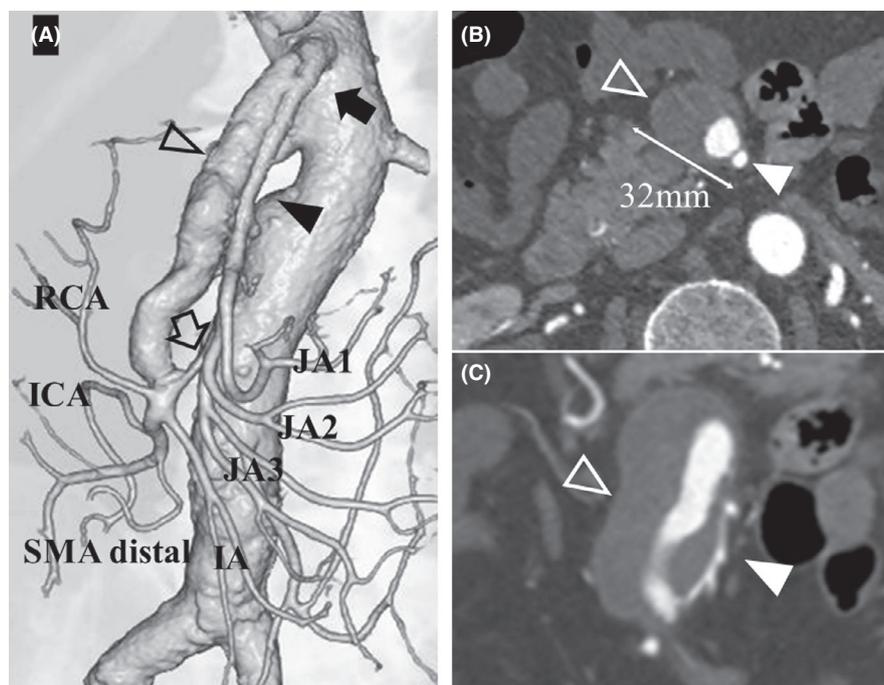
Preoperative computed tomography of the superior mesenteric artery (SMA) and aneurysm. (A) Volume-rendered image. (B) Axial view. (C) Coronal view. The SMA aneurysm has a diameter of 32 mm. The dissection extends 10 mm peripherally from the origin of the SMA to the bifurcation of the ileocolic artery. There is an entry (black arrow) 15 mm from the origin, and a re-entry (white arrow) involving the right colic artery (RCA), ileocolic artery (ICA), and ileal artery (IA). The false lumen (unfilled triangle) is partially thrombosed, and the true lumen (filled triangle) is narrowed due to compression by the false lumen. Three branches of the jejunal artery (JA) originate from the true lumen of the aneurysm
